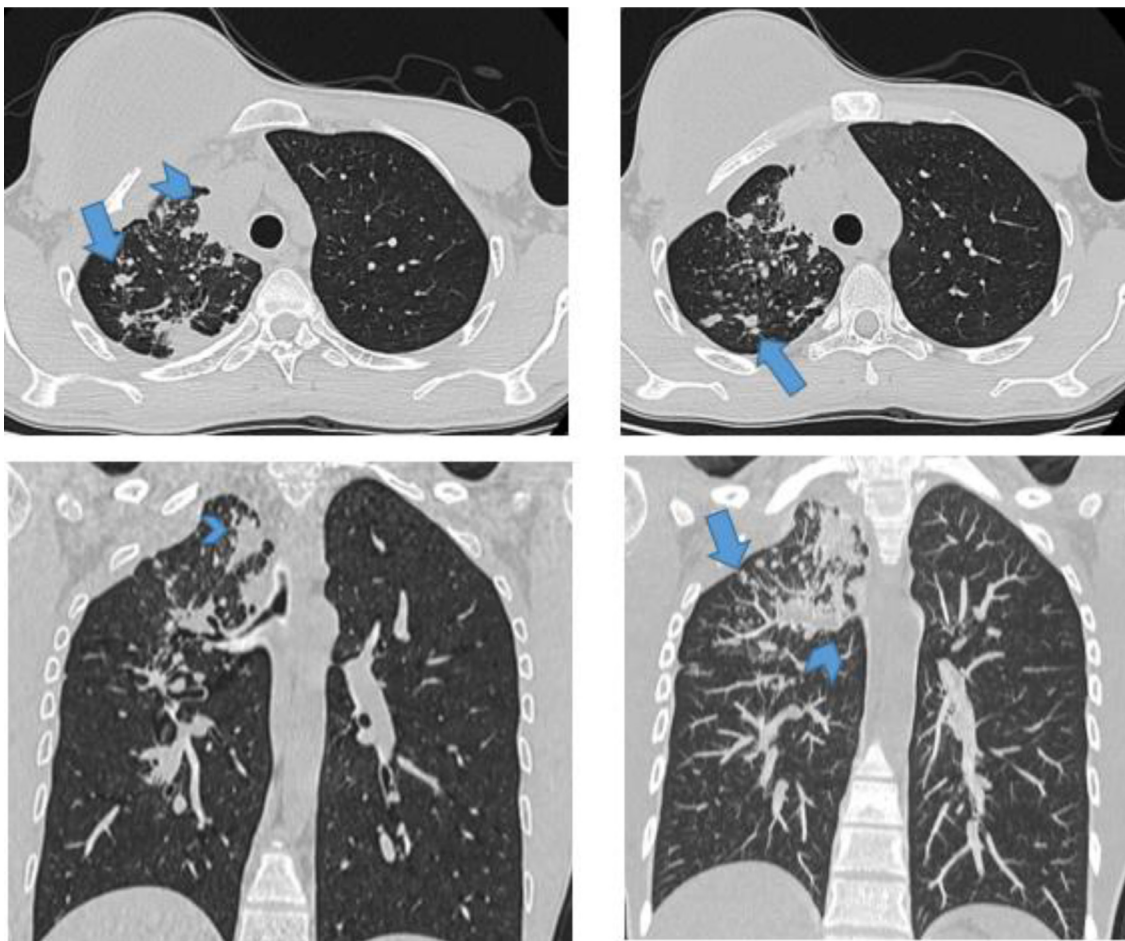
Chest CT: Right upper lobar lung parenchymal nodules and micronodules, with centro-lobular distribution (Arrow). Retractable apical condensation, attracting pleura and bronchial structures (Arrowhead).
